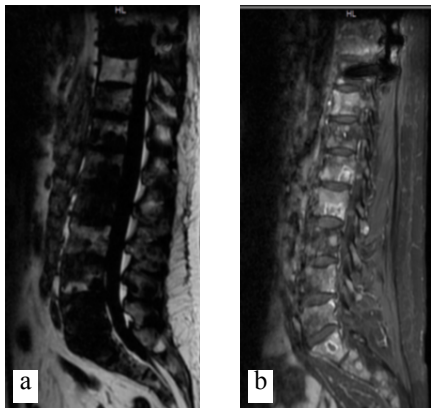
Magnetic resonance imaging (MRI): a and b T1-weighted and STIR images after gadolinium administration, showing widespread diffusion of osteolytic metastases.
